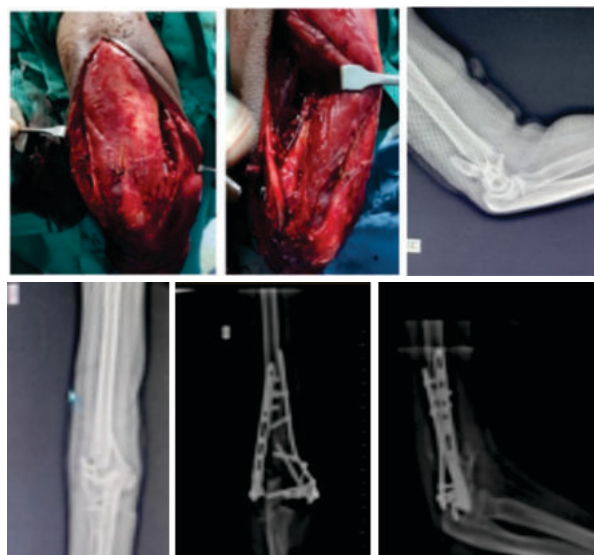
Intra-operative pictures, Pre and Post OP Xray of C2 type distal humerus fracture
